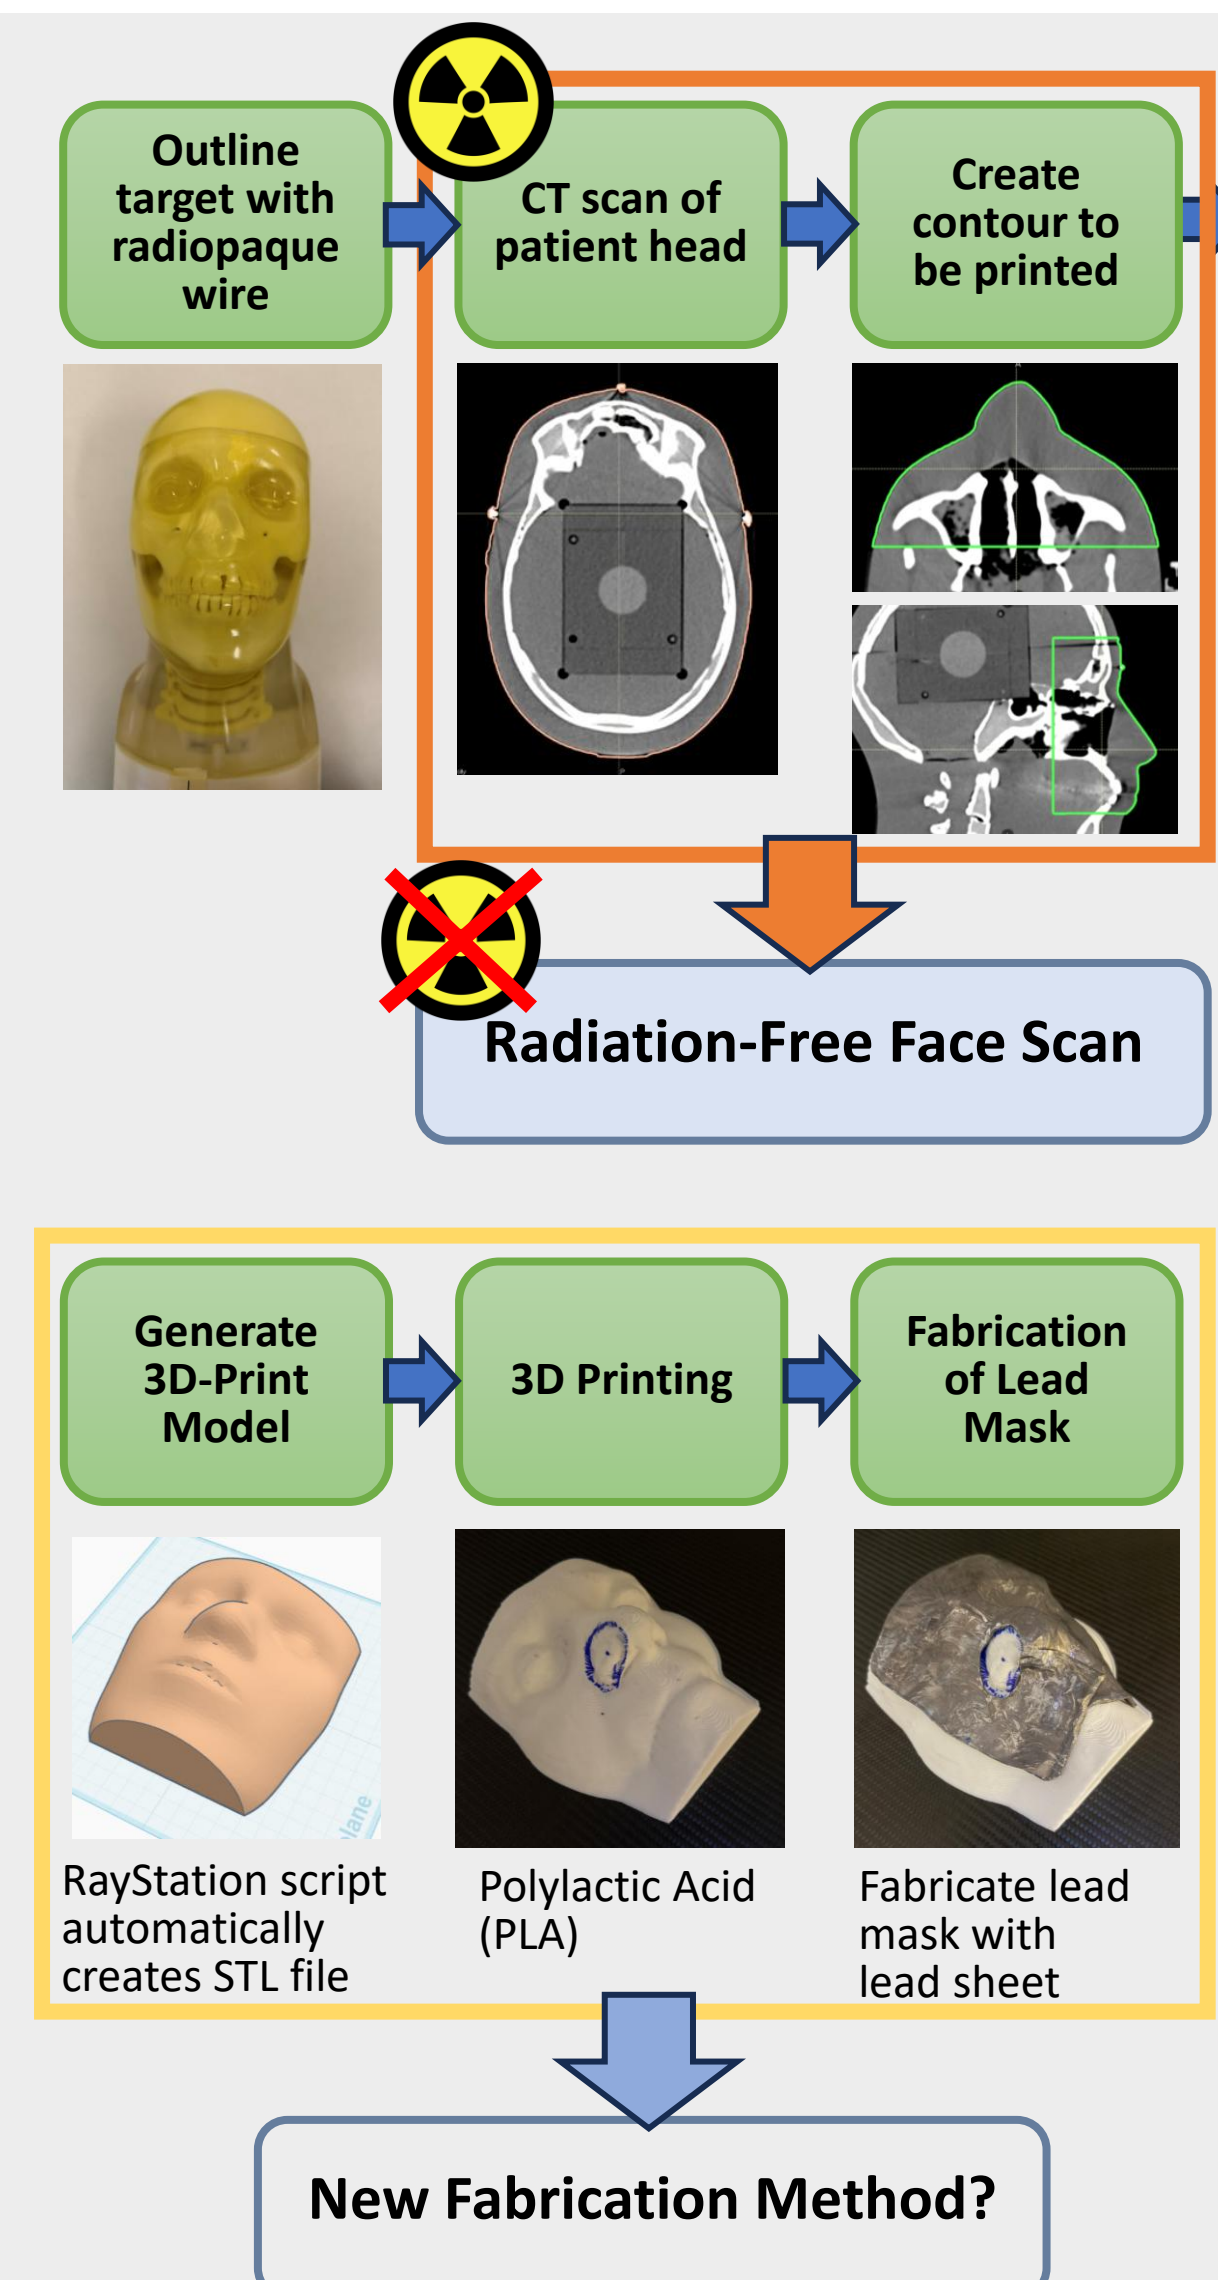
Lead shield fabrication using a 3D printed custom model based on CT scan and Radiation-Free hand-held 3D scanner
